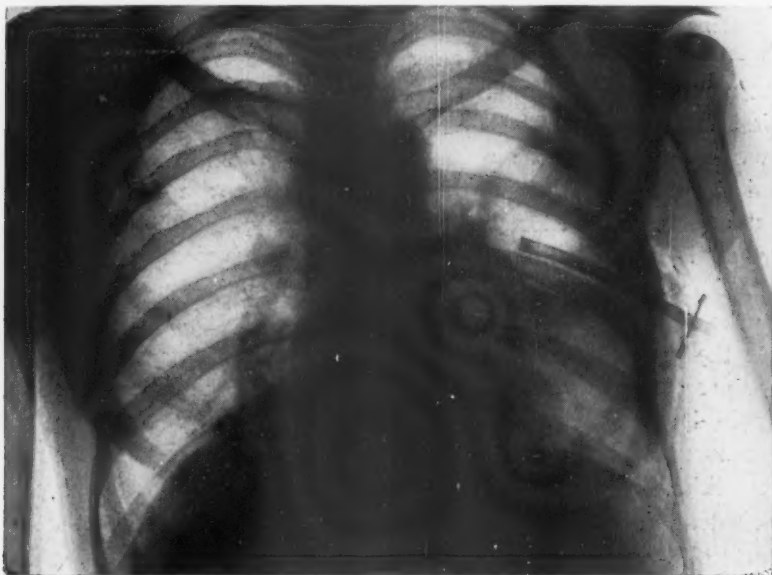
(Case XXIX.) Lung radiograph after the operation.
